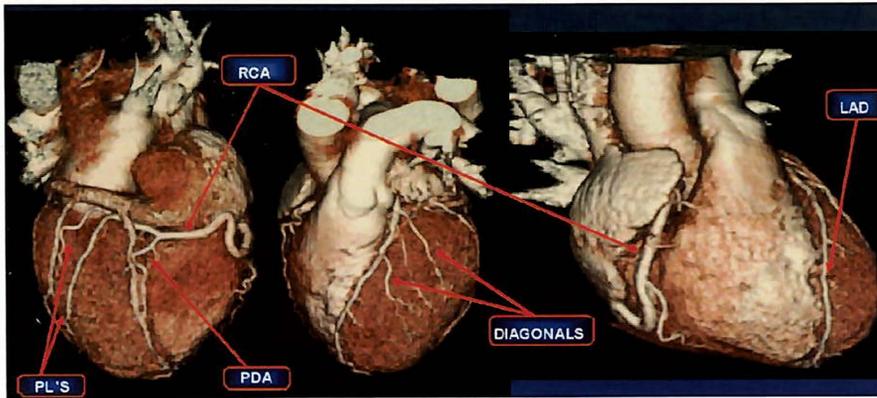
Volume rendered images showing the clarity that can be achieved with CTA. PDA = posterior descending artery; PLS = posterolateral branches; other abbreviations as in Figure 1. (Images provided by John J. Mahmarian, M.O. F.A.C.C., F.A.S.N.C.)
